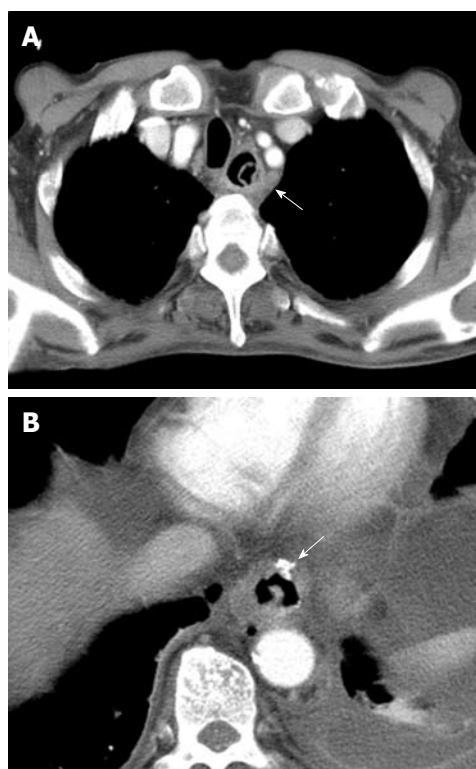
Chest CT images. A: The transverse view of the proximal esophagus shows a concentric intramural hematoma and mucosal dissection with an air-fluid level in the false lumen (arrow). Bilateral pleural effusions are seen; B: The sagittal view shows an extensive intramural hematoma of the esophagus.
